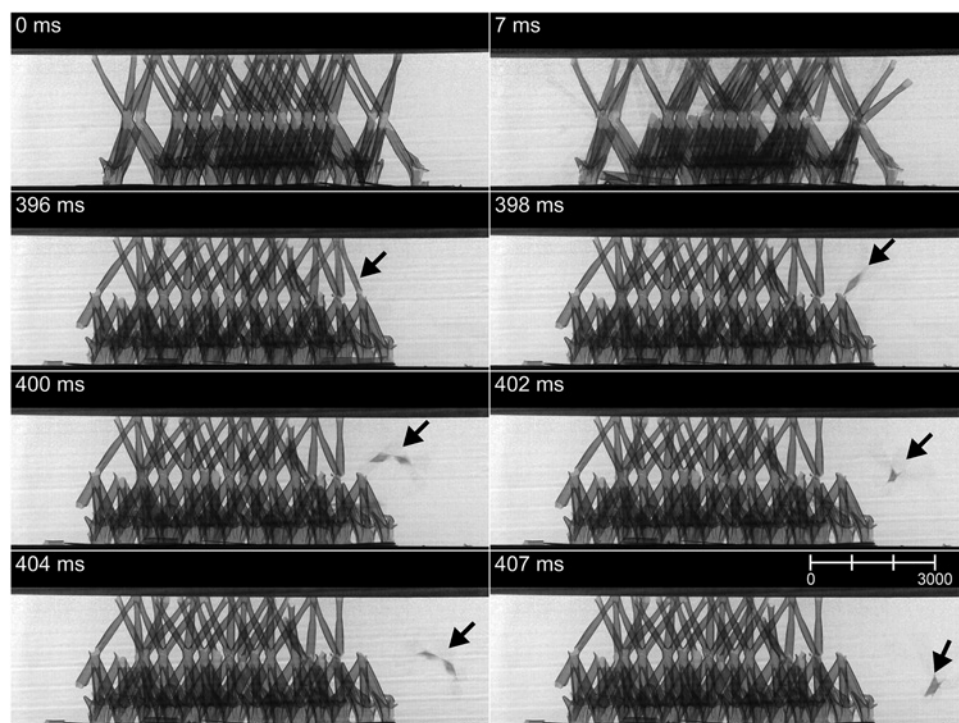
A series of radiographs of a NiP microlattice acquired during dynamic compression. The radiographs show the microlattice at different time intervals (and, consequently, at different rotation angles). The black arrow indicates a ligament that breaks off of the main body of the sample and falls to the bottom of the loading stage. The scale bar is in micrometers.
